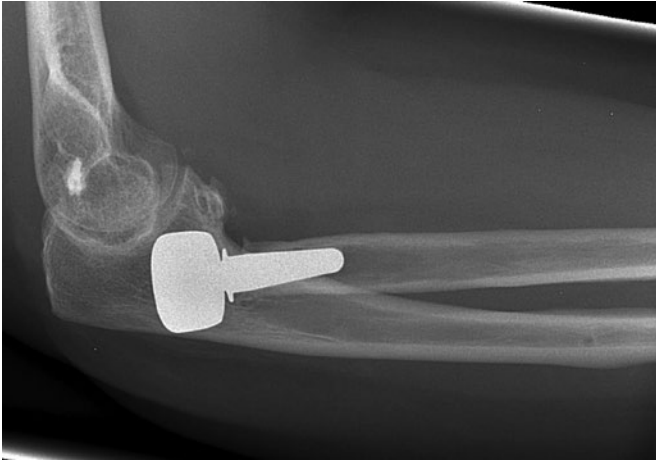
Lateral radiograph of case 29 shows the subluxed position of the press-fit bipolar radial head prosthesis onto the capitellum. There is distinctive proximal osteolysis around the implant.
